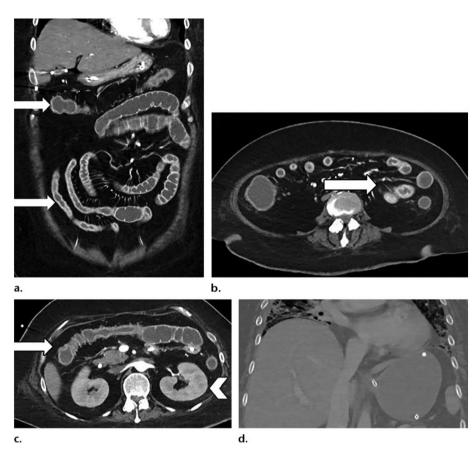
Cough and shortness of breath in a 46-yearold woman (patient no. 22) with diabetes mellitus who was initially diagnosed with COVID-19. The patient's condition clinically deteriorated, and the use of mechanical ventilation, extracorporeal membrane oxygenation (ECMO), and pressor support was required. The clinical course was complicated by acute toxic metabolic encephalopathy, pneumonia, acute respiratory distress syndrome, cardiogenic shock, acute kidney injury, and secondary adrenal insufficiency. Coronal (a) and axial (b, c) contrastenhanced CT images show multifocal small and large bowel wall thickening (arrows) creating a ribbonlike appearance, likely related to small vessel ischemia. Note the altered enhancement of the kidneys (arrowhead in c) in the setting of acute kidney injury and multifocal peripheral airspace opacities at the lung bases on the coronal CT image (d). Images obtained from Olson et al.29 Radiology published online on July 10, 2020, Vol. 40, No. 5, copyright (2020), and permission to use granted by Ashley E. Daly, Senior Manager, Journal Rights & Communications Publications, Radiological Society of North America (RSNA).
